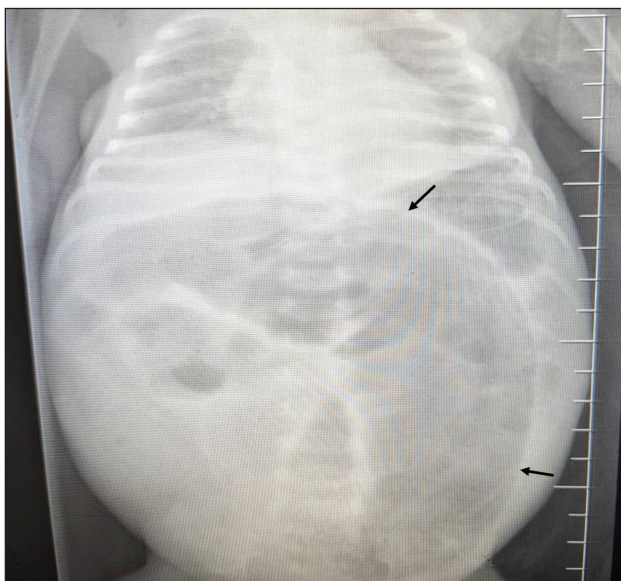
Abdominal X-ray demonstrating distal small bowel obstruction, characterized by markedly dilated intestinal loops (black arrows) with air-fluid levels, suggesting impaired distal bowel passage and luminal obstruction.
